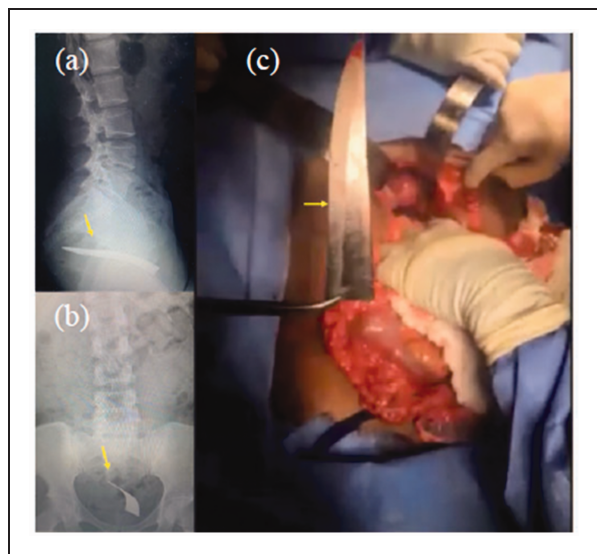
Distance mentoring in a patient undergoing laparotomy for a stab wound. Inset: retained blade is seen in plain radiographs on lateral (a) and antero-posterior (b) views. The operative field as seen by the mentor by videotelephony (c).
